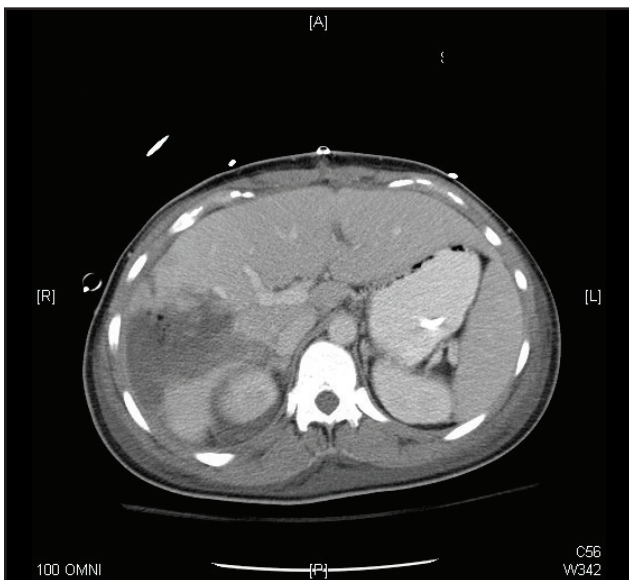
CT scan of a high-grade liver laceration following a motorcycle accident. The patient developed a bile duct injury as well.
